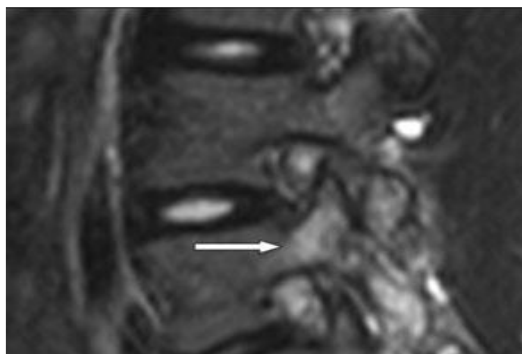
MRI Scan showing pars fracture [white arrow]
